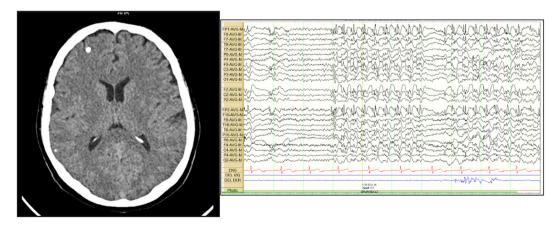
Plain CT scan of the skull (left) and electroencephalogram (right).
